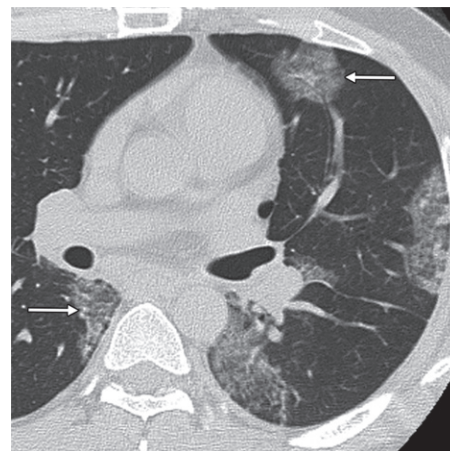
Influenza A virus infection in a 40-year-old woman with a history of acute cough, a recent onset of fever, and an equivocal chest radiograph (not shown). Axial chest CT image (lung window) shows peripheral focal ground-glass opacities (arrows) in the left upper lobe and both lower lobes.
